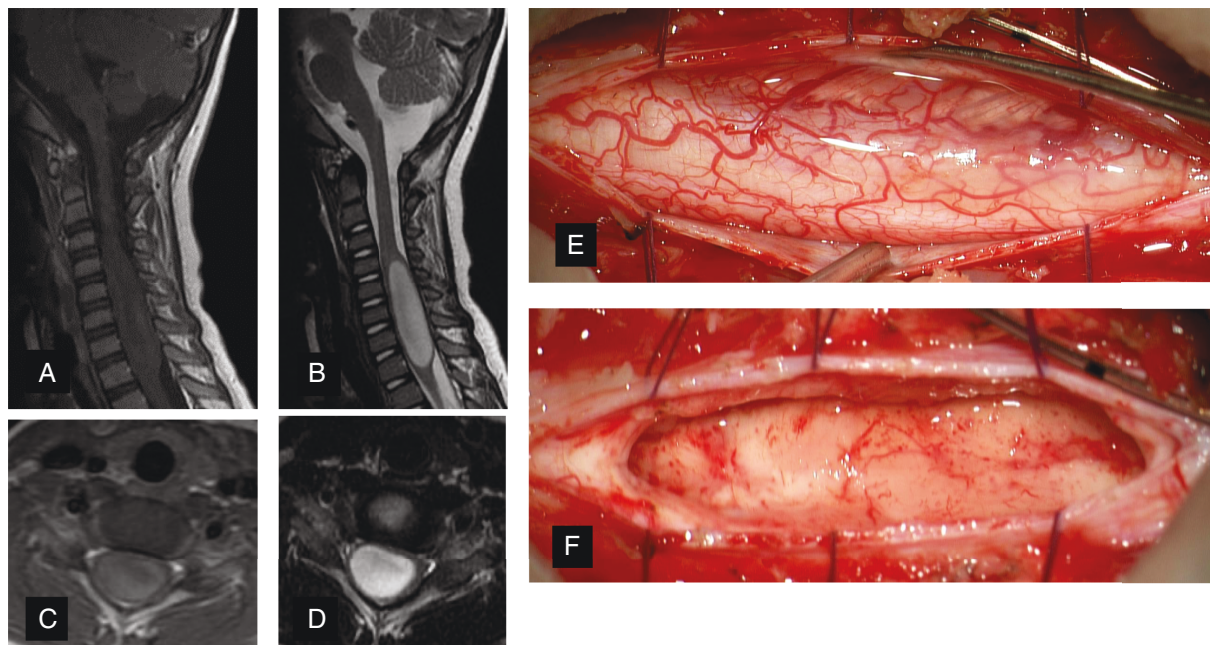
Infant with intramedullary pilocytic astrocytoma CNS WHO grade 1. A/C: Axial and sagittal contrast enhanced T_1 -weighted MRI, B/D: Axial and sagittal T_2 -weighted MRI, E: spindle-shaped bulging of the myelin, F: complete resection within clear margins after midline myelotomy.
